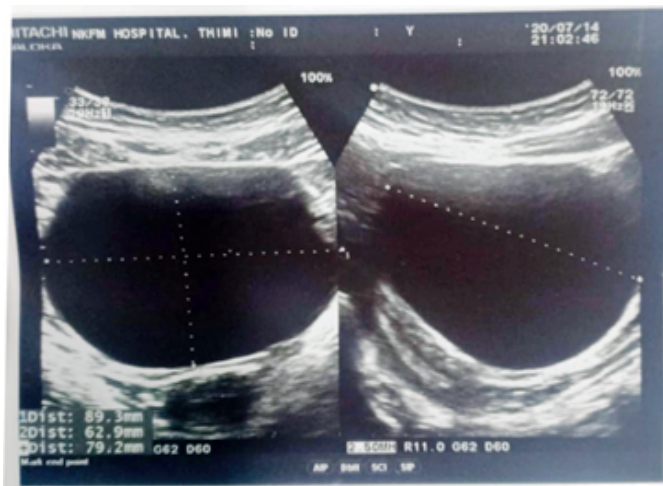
Transabdominal Ultrasound Showing Uniloculated Cyst Without Internal Vascularity, Calcifications, Mural Nodules or Septations
